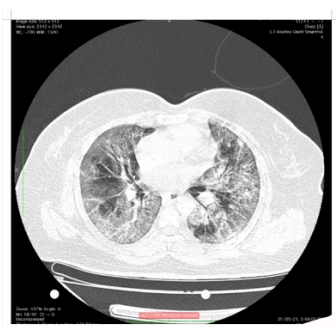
A. Transverse section of CT-Chest
